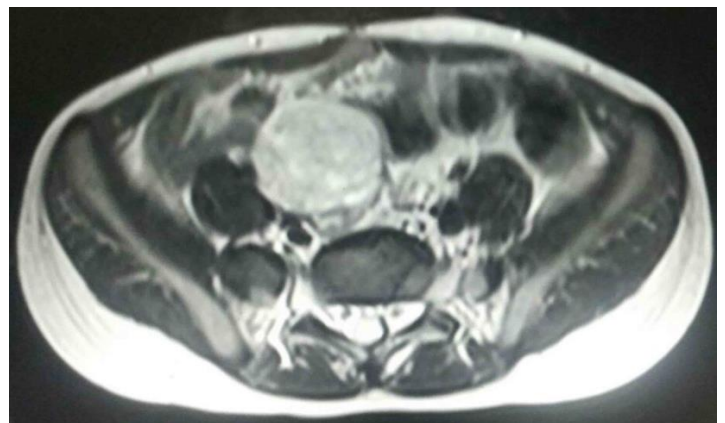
Contrast enhanced MRI showed altered signal intensity mass of about 3.5x3.8x3.8cm in the pelvis in front of S1 to L5 vertebra with intense heterogeneous post contrast enhancement and few centrally placed areas of necrosis.
